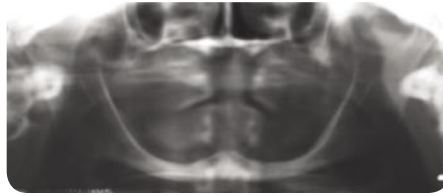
Preoperative radiograph showing the inadequate bone for implant placement.
